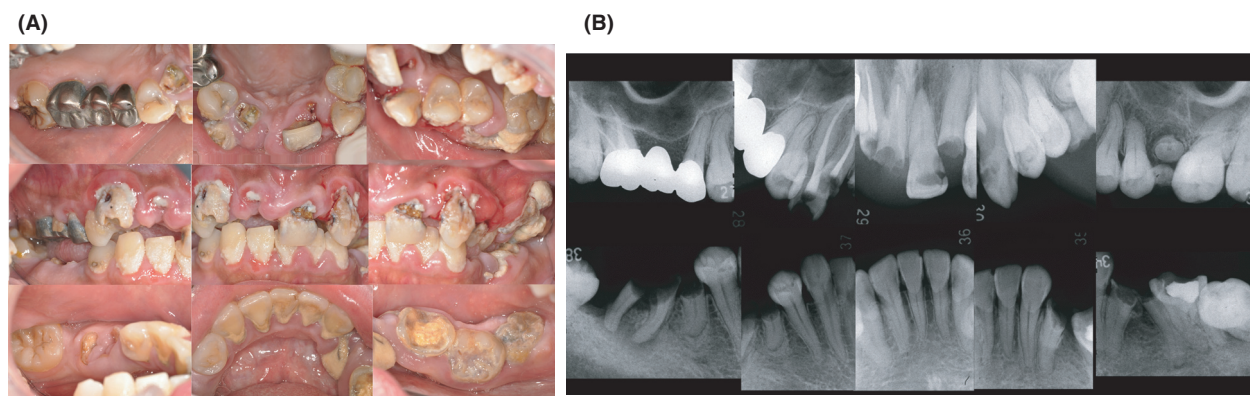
Intraoral view (A) and radiographs (B) at baseline. (A) Inflamed gingiva (redness and swelling) and decayed teeth with cavities due to dental biofilm are visible. (B) Alveolar bone resorption (radiolucencies around teeth) and decayed teeth (radiolucencies in teeth) suggest the existence of infectious focus.
